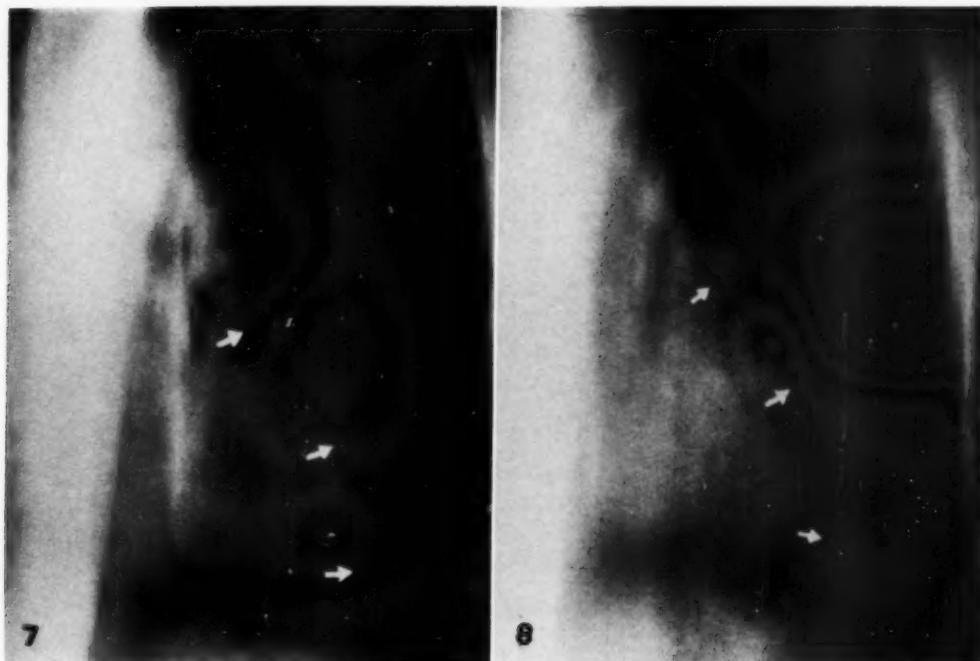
Planigraphic roentgenogram of heart (J. M.) on Aug. 25, 1952, demonstrating a curvilinear shadow of increased radiolucency 2 cm. within the apparent left heart border. This is interpreted to represent the subepicardial fat layer and to afford visualization of the adjacent thickened pericardium measuring 2 cm. in width. On the basis of roentgenoscopic study it was determined that the abnormal shadow was produced by a thickened fibrinous pericardium rather than by pericardial effusion.
